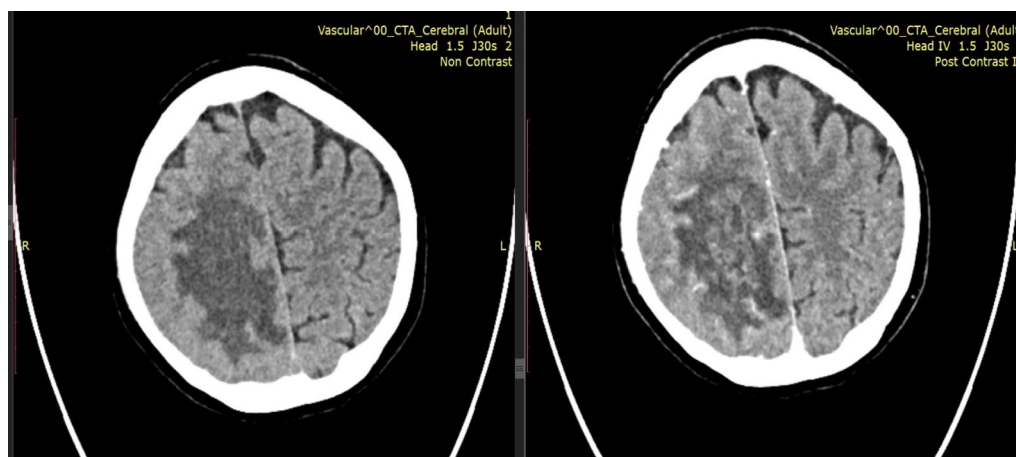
Axial brain CT images show right frontal and posterior parietal white matter edema in plain or non-contrast CT brain (left) and peripheral lesions are enhanced in post-contrast CT brain (right)
